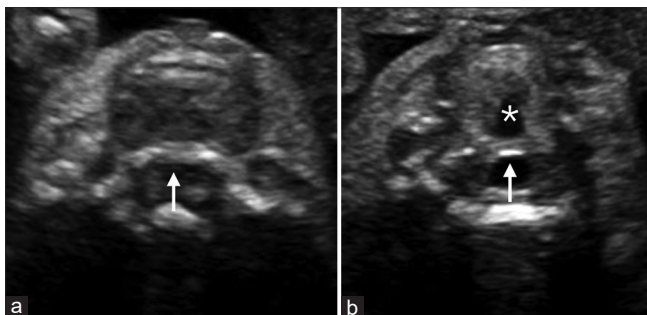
A series of two-dimensional grayscale ultrasound images for advanced orofacial cleft screening. Additional advanced screening views include the posterior edge of the hard palate (arrow, a) and soft palate (arrow, b). The space between the tongue root and soft palate becomes observable during fetal swallowing (asterisk, b). The applied approach for the assessment of the soft palate during fetal swallowing was described in detail elsewhere [11]
